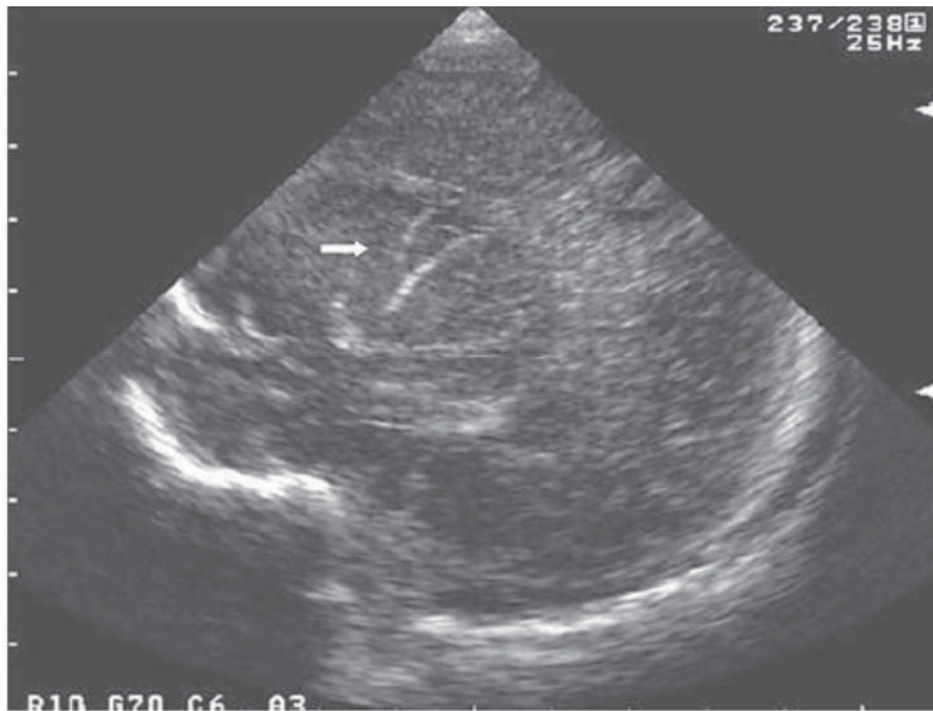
Cranial ultrasound (sagittal view) in a neonate with lenticulostriate vasculopathy, showing the typical branching hyperechogenic lesions in the thalamus and basal ganglia (arrow).
